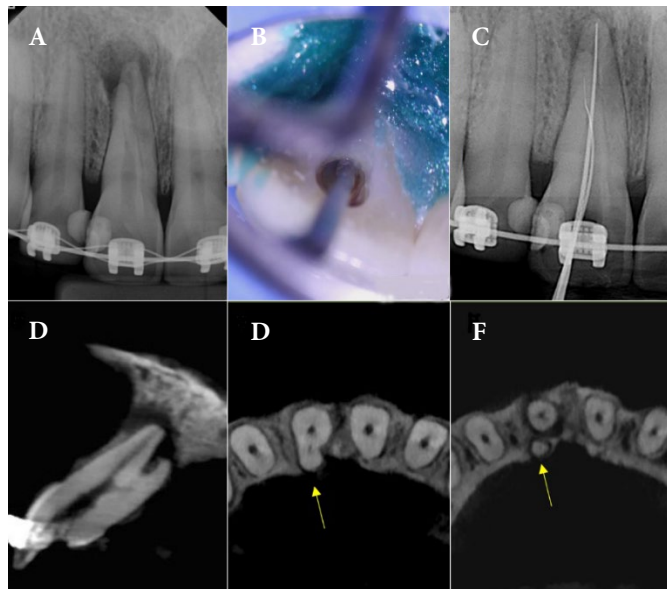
A) An initial X-Ray; B) E6D ultrasonic tip wearing out the cervical palatine dentin interference; C) files reaching the working length; D) Two root canals on the CBCT scan in sagittal section; E & F) Axial sections; note the additional canal in the palatine region (yellow arrows)
